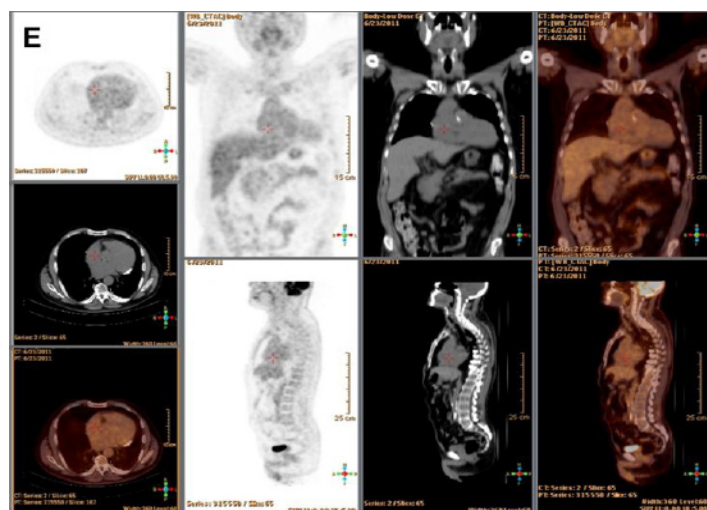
June 2011–18F-FDG PET/CT scan after 7 of 8 courses of chemotherapy (R-COMP) demonstrated radiotracer uptake normalization in the right atrium (SUV max of 1.9 versus pre-treatment value of 9.4): the right atrial lymphoma relapse showed a complete metabolic response to treatment.
